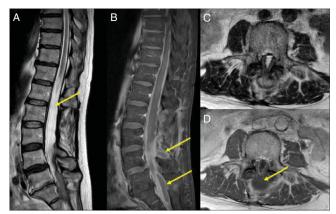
T2-weighted (A, C) and contrast-enhanced T1-weighted (B, D) images show increased T2 prolongation within the cauda equina and thecal sac with rim-enhancing collections.
